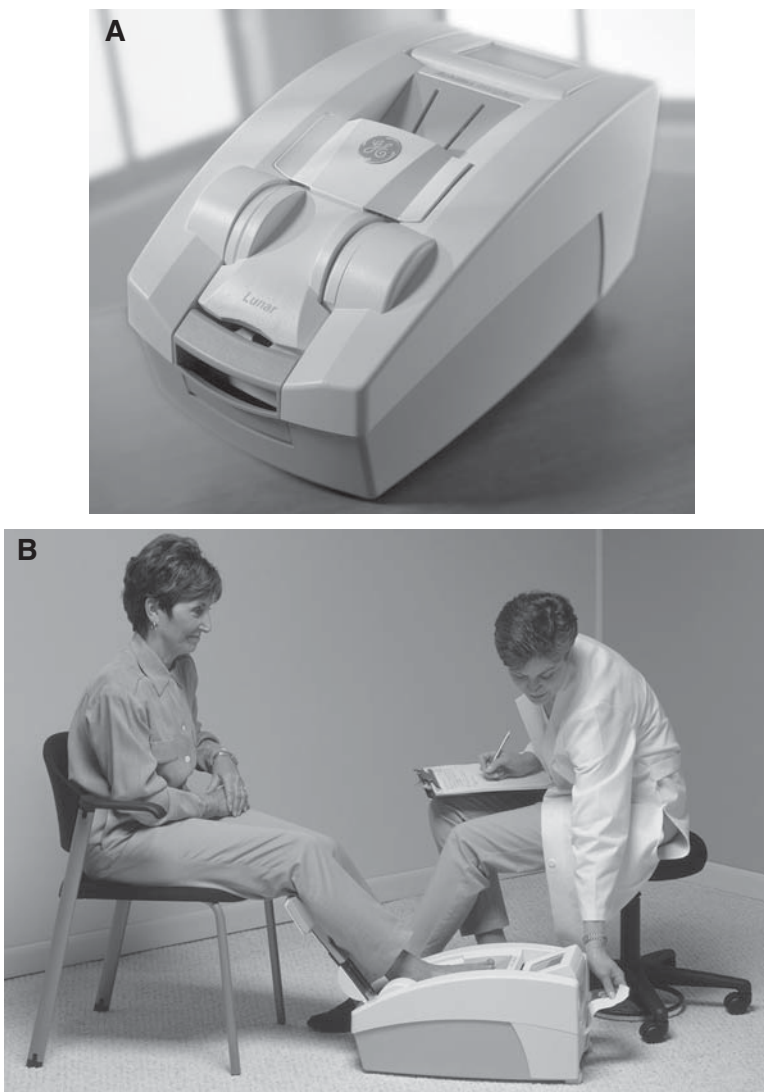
(A) The Lunar InSight™. A peripheral quantitative ultrasound device used to measure the calcaneus. (B) The Lunar InSight™ shown in use. Photographs courtesy of GE Medical Systems, Madison, WI.
